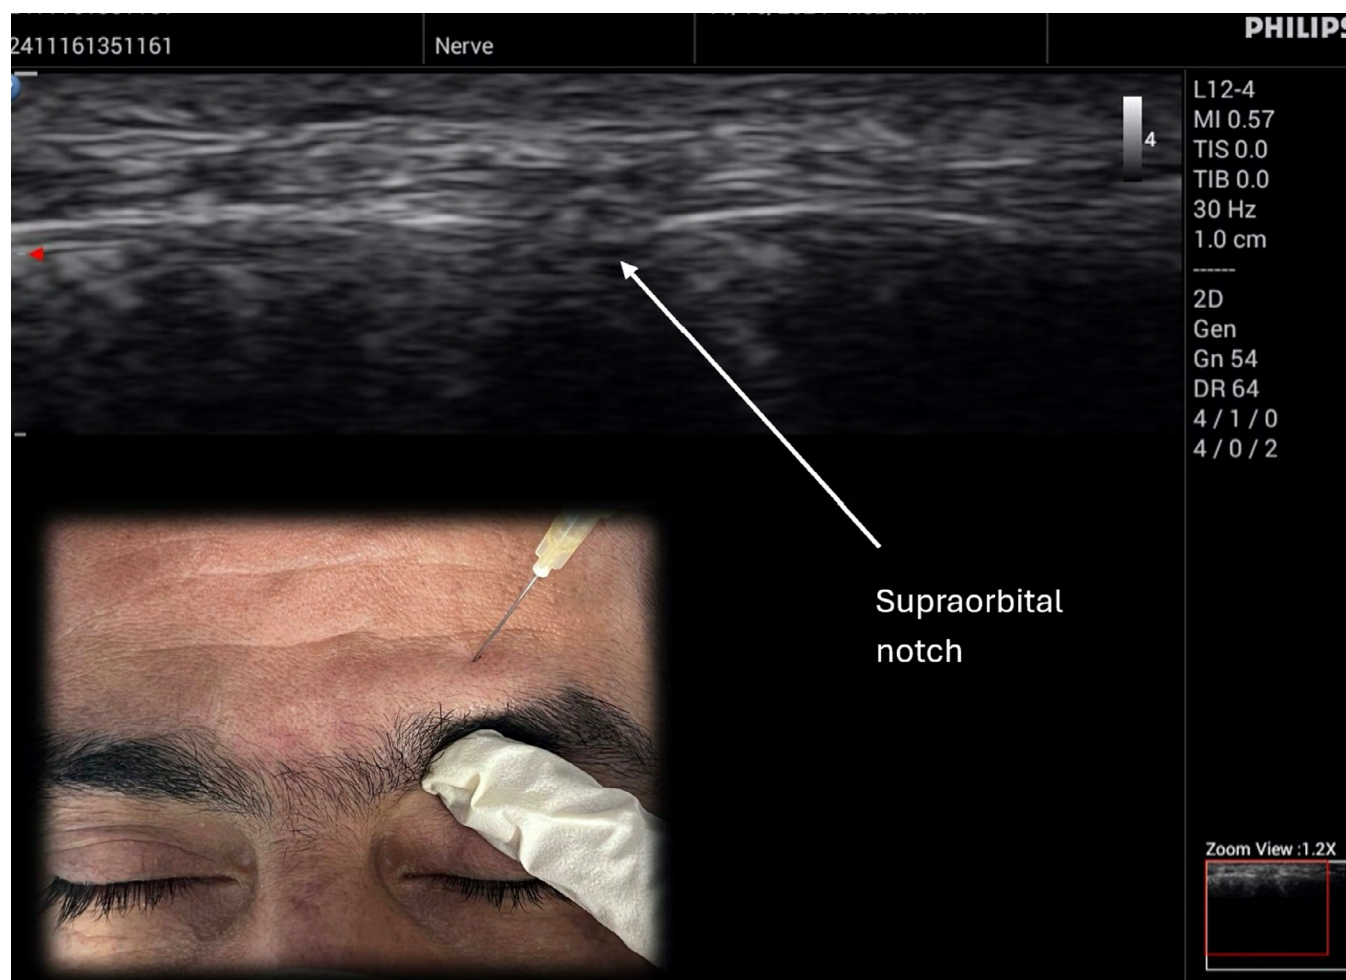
Sonographic vs anatomical landmark of supraorbital nerve block.
